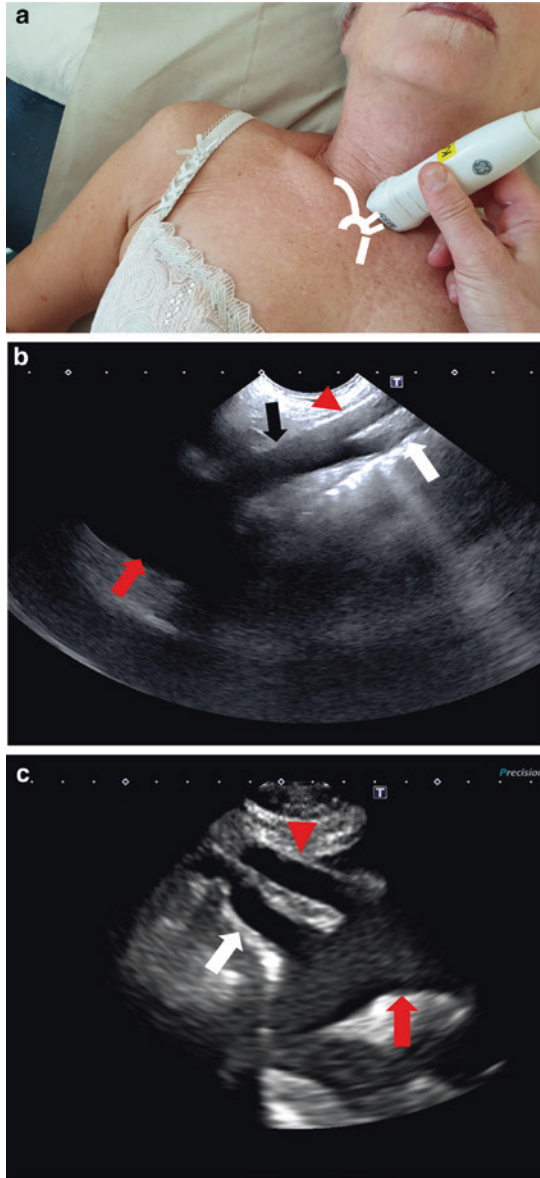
Examination of the aortic arch: a recommended transducer position, b ultrasonographic view of the brachiocephalic trunk (black arrow), carotid artery (red arrowhead), subclavian artery (white arrow), aorta (red arrow), right side c carotid and subclavian artery, aorta, left side
